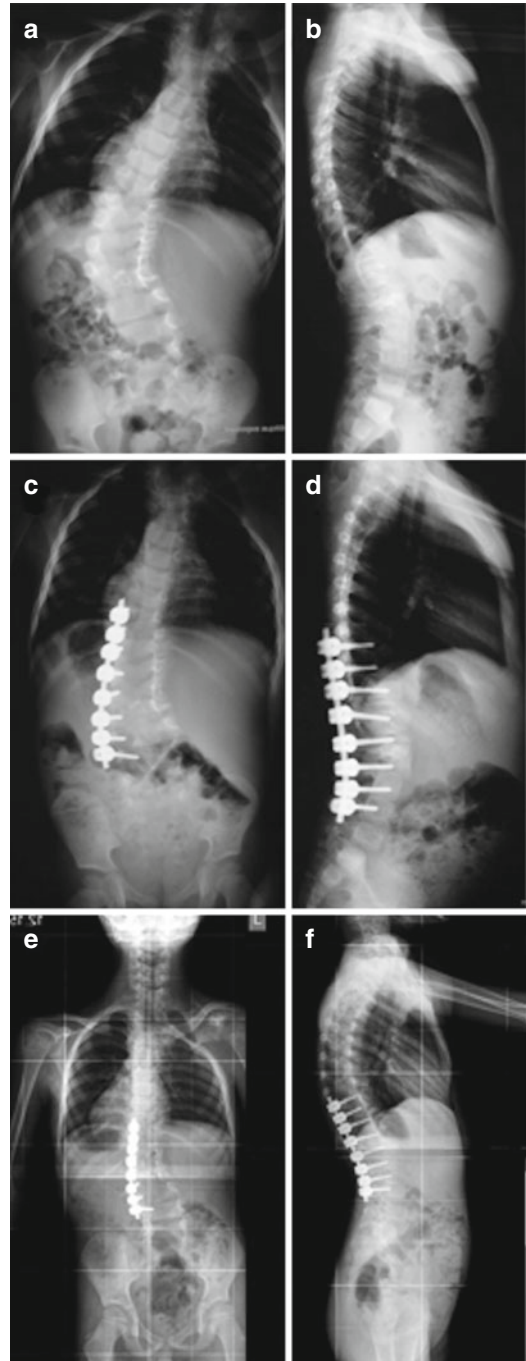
A six-year-old male with (a) thoracolumbar coronal deformity and (b) normal sagittal alignment was treated with instrumented convex growth arrest. Postoperatively the patient had improved coronal alignment (c), and the sagittal alignment is positive on lateral radiograph (d). At 5-year follow-up, the coronal deformity further improved (e), and the sagittal contour appears to have reconstituted to normal (f)
